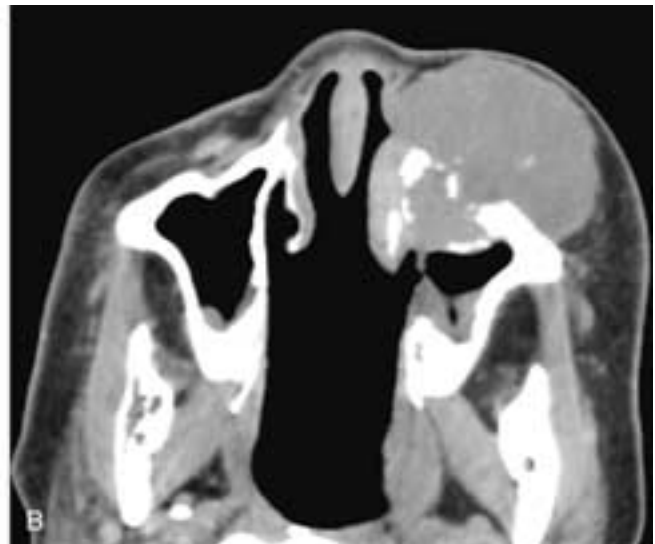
Coronal (A) and axial (B) CT scans through the paranasal sinuses show a destructive soft tissue mass in the left maxillary sinus. Part of the nasal septum had been removed at the time of prior surgery. This patient developed a recurrent chordoma along the course of the original operative procedure for a skull base chordoma.
